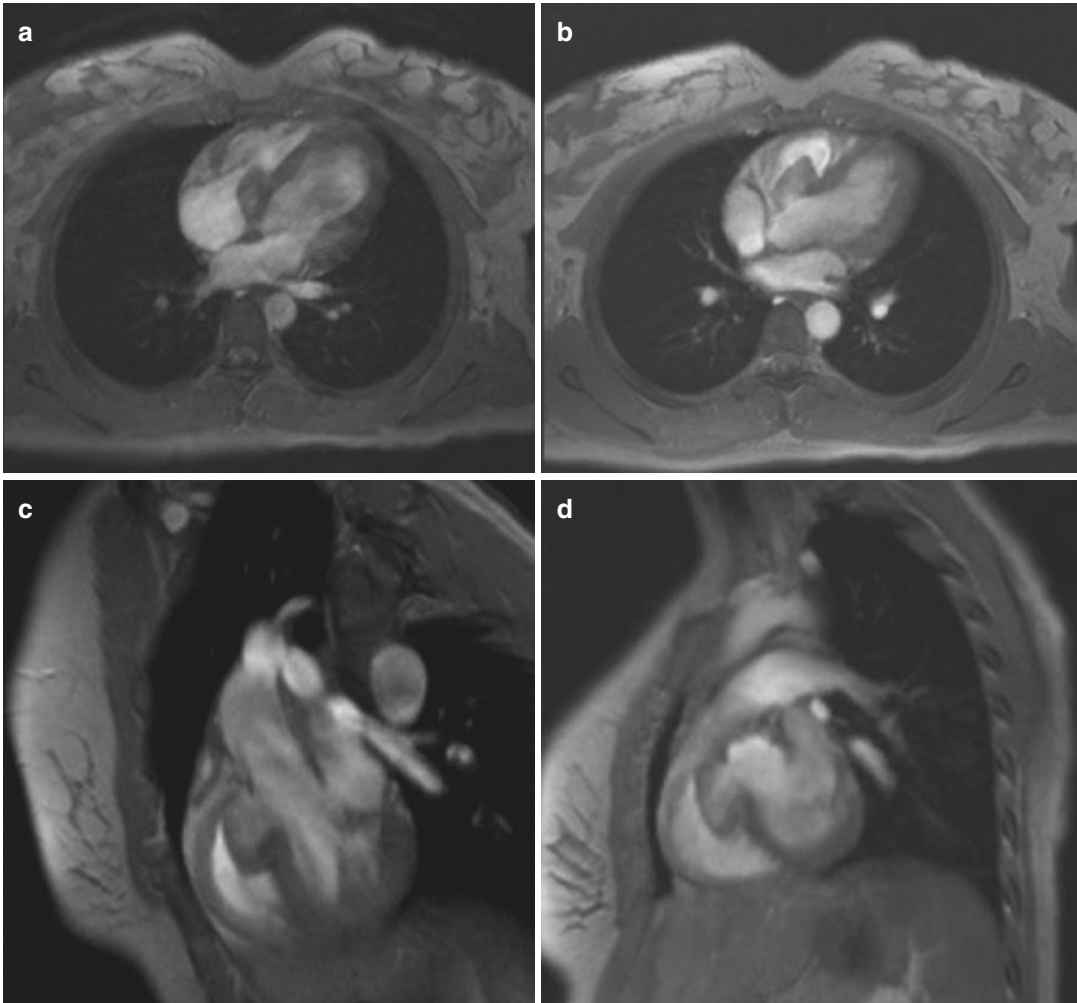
Aneurysm of the membranous interventricular septum at cine FLASH MRI sequence. (a), (b) Four-chamber view, (c) three-chamber view, and (d) short-axis view images show a large aneurysm of the membranous interventricular septum protruding into the right ventricle
